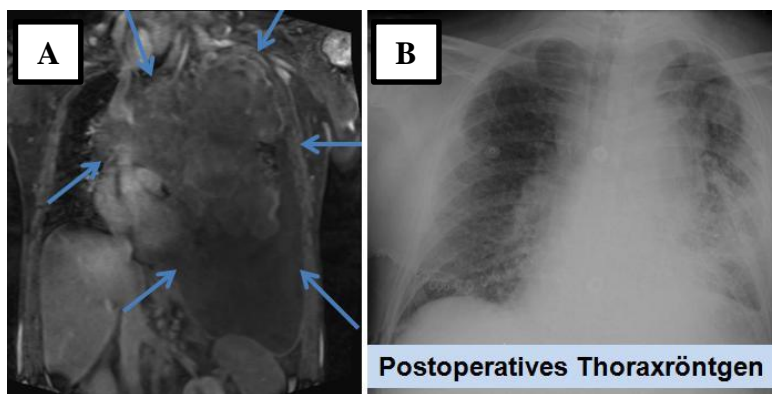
Magnetic resonance image (A) of a not completely resectable TC. Because of upper inflow occlusion and severe compromise of cardiorespiratory function the patient was not amenable to ChT. After incomplete resection of the TC regular cardiorespiratory conditions allowed adjuvant ChT (postoperative chest X-ray (B)). From (Moser and Klepetko 2013).
